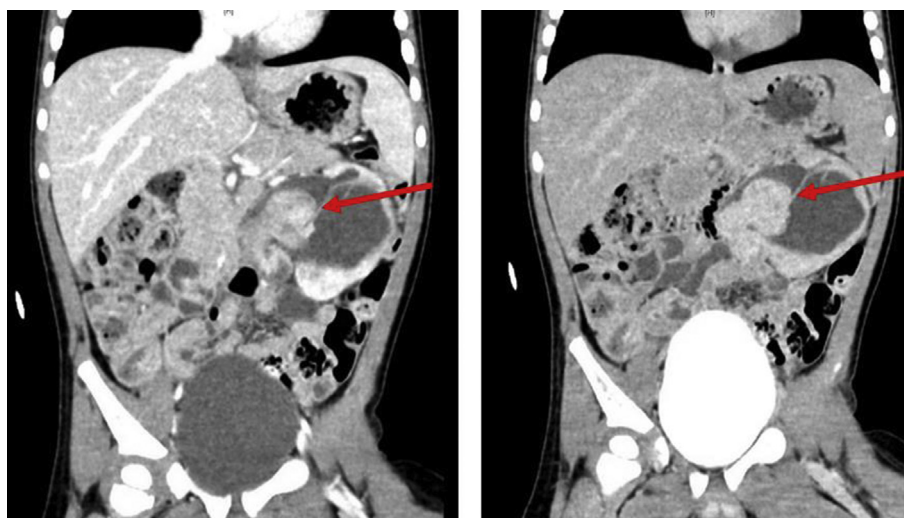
CT with contrast arterial phase (left) and delayed phase (right) demonstrated an enhancing, rounded mass at the level of the left UPJ with extension into the proximal ureter along with several other smaller enhancing mass-like lesions within the lower pole collecting system.
